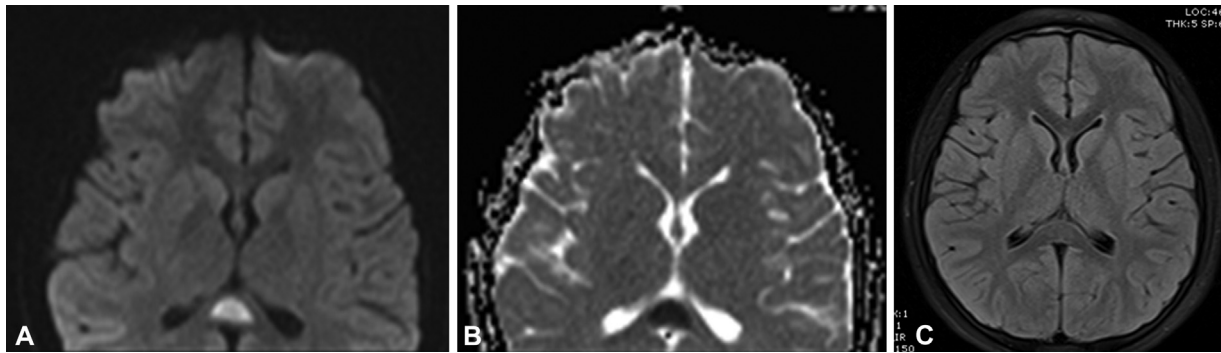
11-year-old with transient splenial lesion. (A) Axial DWI and (B) axial ADC images show a well-defined focus of diffusion restriction involving the mid-portion of the splenium of the corpus callosum. Axial FLAIR image (C) shows corresponding hyperintensity involving the splenium of the corpus callosum. ADC, apparent diffusion coefficient; DWI, diffusion-weighted images; FLAIR, fluid-attenuated inversion recovery.
